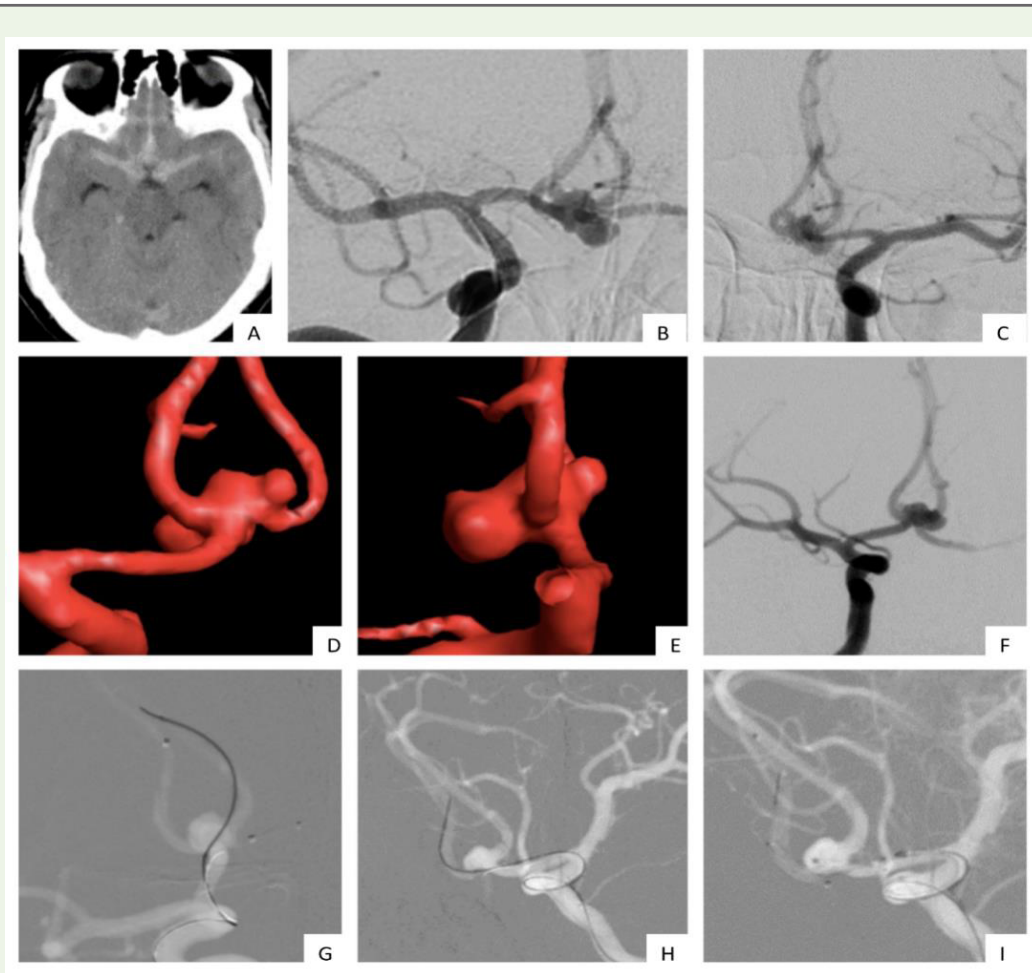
Plain CT brain in axial section depicts diffuse subarachnoid hemorrhage (Figure 1A). Right (Figure 1B) and left (Figure 1C) internal carotid artery angiogram shows a bilobed aneurysm – with the lobes extending superiorly and inferiorly. Internal carotid angiogram in anteroposterior view (Figure 1D) and lateral view (Figure 1E) demonstrate extremely wide necked anterior communicating artery aneurysm measuring 8x6x7mm. Internal carotid angiogram in anteroposterior view shows working projection for unsuccessful attempt to negotiate wire and catheter into the ipsilateral A2 segment (Figure 1F). Hence, the plan was changed to X stenting. 2 catheters were negotiated from left A1 segment to right A2 segment (Figure 1G) and right A1 segment to left A2 segment respectively (Figure 1H). A third catheter was placed into the aneurysmal sac for jailing of micro catheter (Figure 1I).
